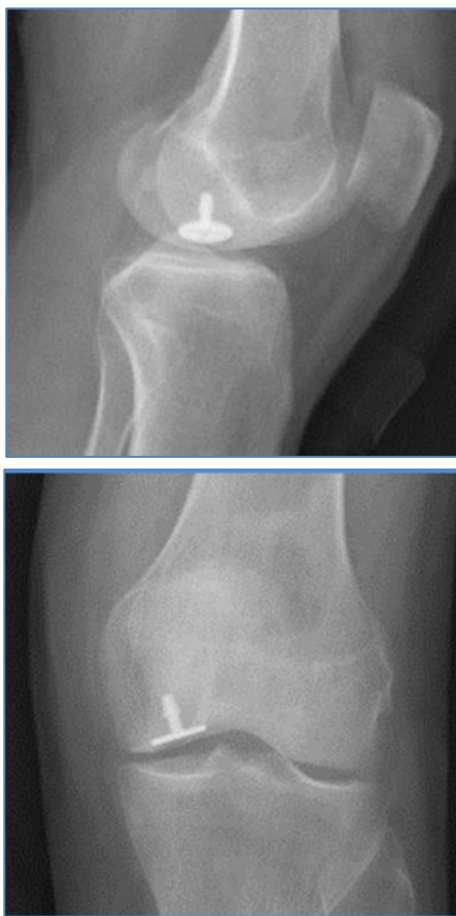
Partial hemiarthroplasty patient's post-operative radiographs at 24 months
